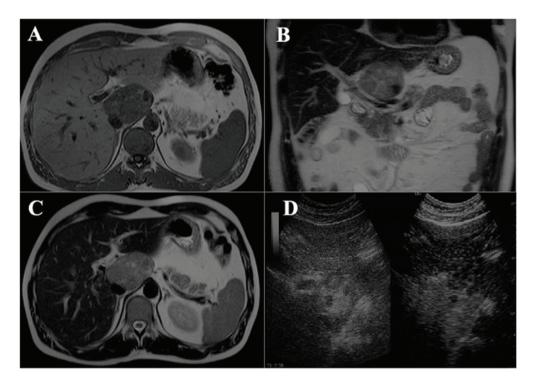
Imaging studies. (A-C) Magnetic resonance imaging of the hepaticlesion. (D) Contrast-enhanced ultrasound of the liver.
